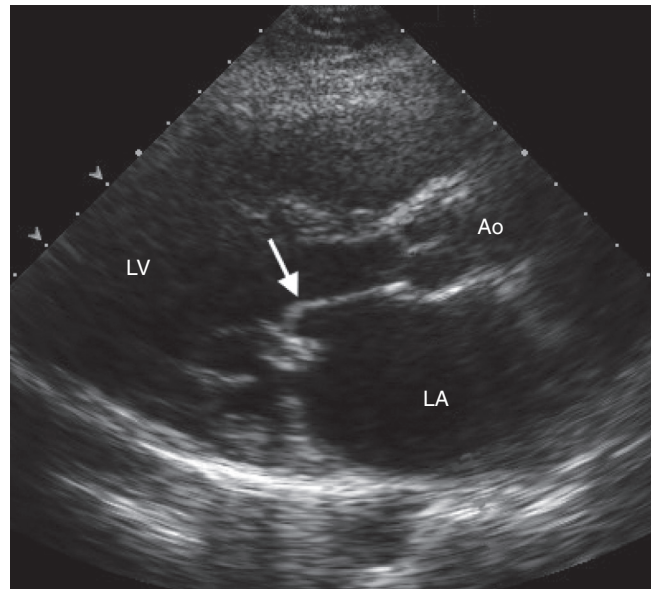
■ Parasternal long axis view during diastole with mitral valve calcification and restricted leaflet opening in a patient with rheumatic mitral valve stenosis. There is also diastolic doming of the anterior leaflet (arrow). Ao, Aorta; LA, left atrium; LV, left ventricle.
